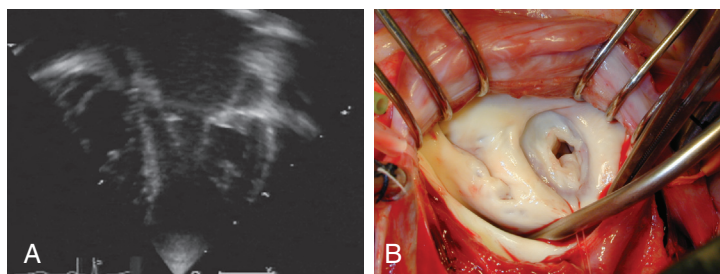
■ A, Two-dimensional echocardiogram of supravalvar mitral ring, apical view. The membrane attached at mid height of the anterior leaflet is characteristic. The posterior part of the membrane is only suggested by the hyperechogenicity of the posterior annulus. B, Intraoperative photograph of a supravalvar mitral ring. Note the implantation of the supravalvar mitral ring high close to the annulus on the posterior leaflet side (*inferior side of the picture*) and at the mid level of the anterior leaflet (*left side of the picture*).
